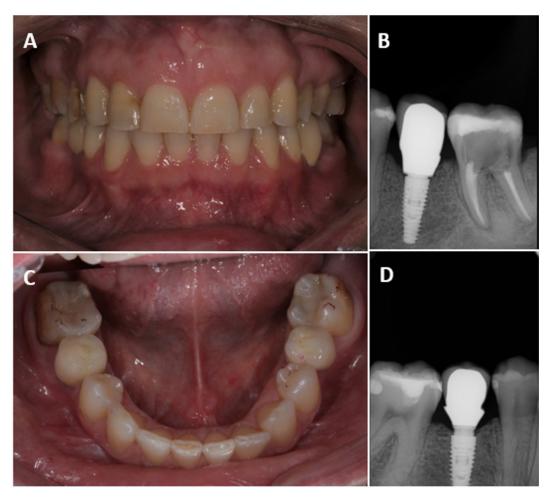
A) and C) Frontal and occlusal view of final protheses. B) and D) Periapical x-rays of rehabilitation of #35 and #45.
